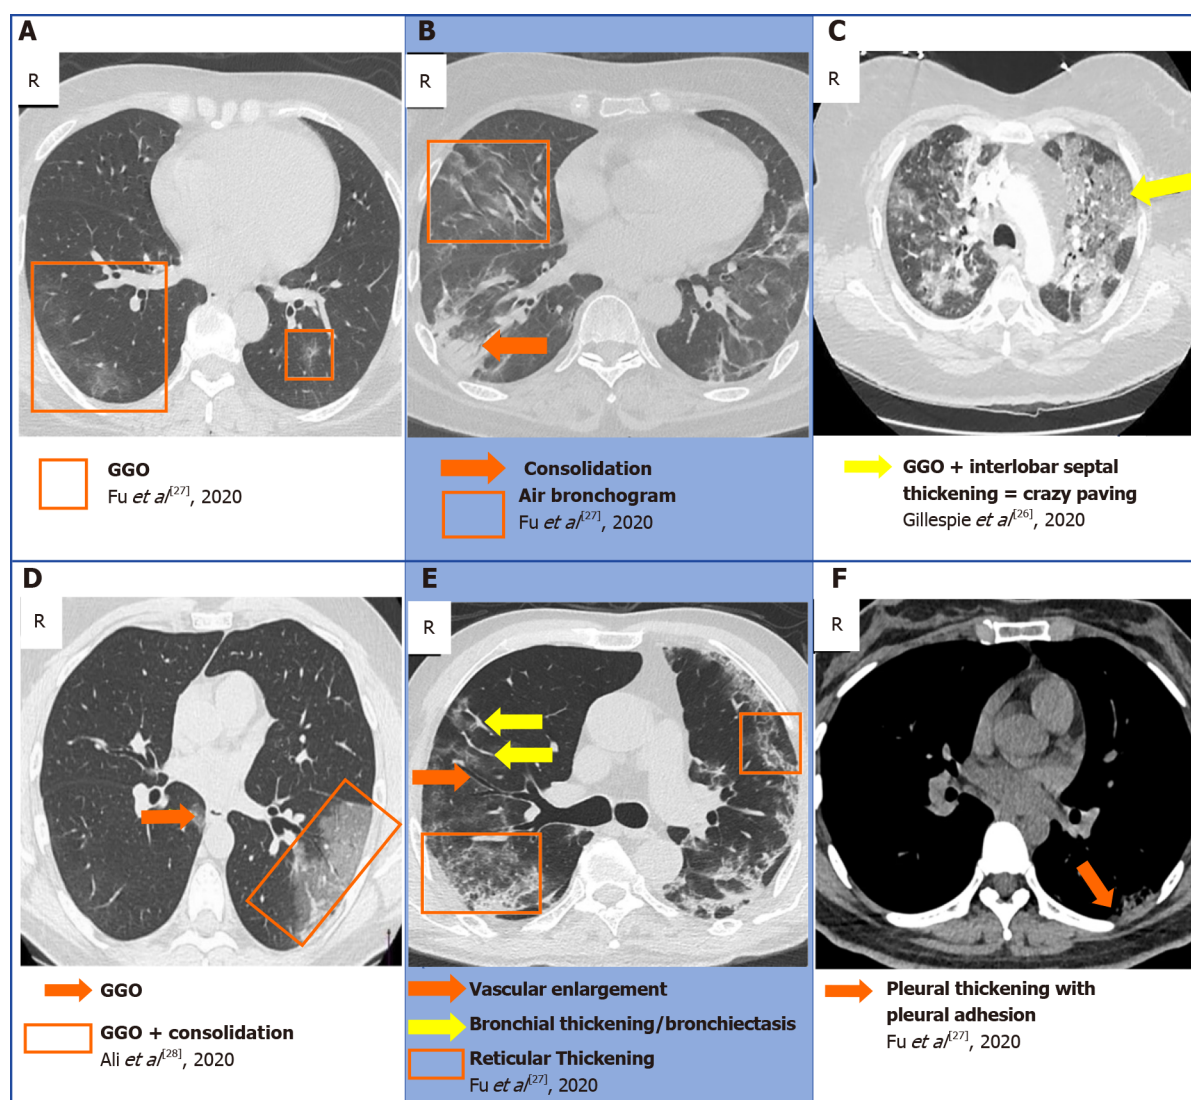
A collection of chest computed tomography that displays some of the classical findings of coronavirus disease 2019 pneumonia[26-28]. A: Ground-glass opacity (GGO); B: Consolidation and air bronchogram; C: Crazy paving; D: GGO superimposed with consolidation; E: Bronchiectasis, reticular thickening, with vascular enlargement; F: Pleural adhesion. A, B, E and F: Citation: Fu Z, Tang N, Chen Y, Ma L, Wei Y, Lu Y, Ye K, Liu H, Tang F, Huang G, Yang Y, Xu F. CT features of COVID-19 patients with two consecutive negative RT-PCR tests after treatment. *Science Report* 2020; 10: 11548. Copyright ©The Author(s) 2020. Published by Springer Nature; C: Citation: Gillespie M, Flannery P, Schumann JA, Dincher N, Mills R, Can A. Crazy-Paving: A Computed Tomographic Finding of Coronavirus Disease 2019. *Clinical Practice and Cases in Emergency Medicine* 2020; 4: 461-463. Copyright ©The Author(s) 2020. Published by UC Irvine; D: Citation: Ali TF, Tawab MA, ElHariri MA. CT chest of COVID-19 patients: what should a radiologist know? *Egyptian Journal of Radiology and Nuclear Medicine* 2020; 51: 120. Copyright ©The Author(s) 2020. Published by Springer Nature.
